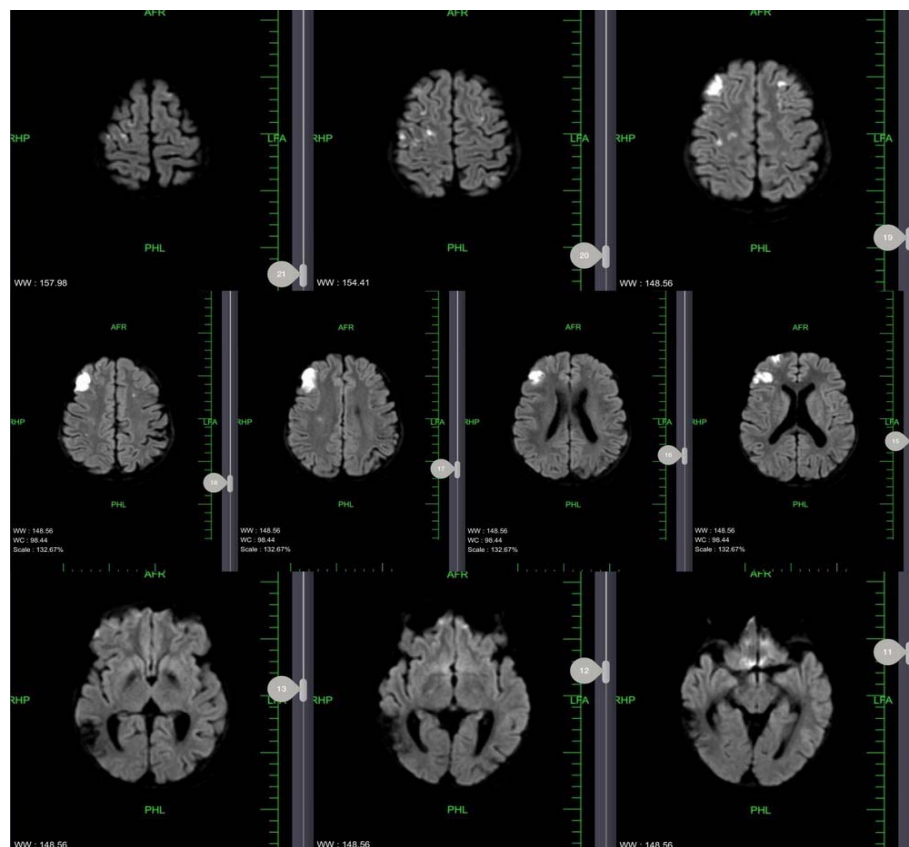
brain MRI , DWI sequences , november 2024
